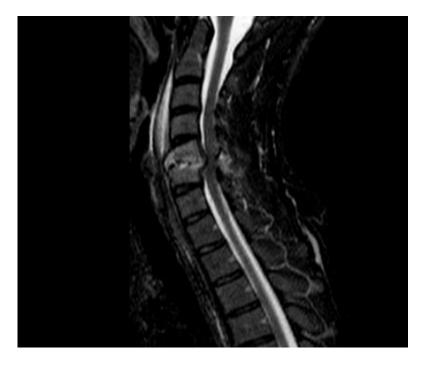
Two weeks later discitis plus new osteomyelitis on MRI STIR sequence
